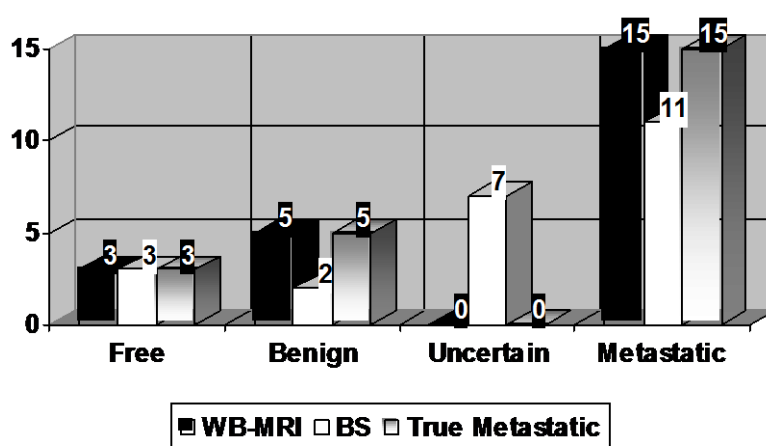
Final diagnosis of each of the 23 cases by WB-MRI and BS.
